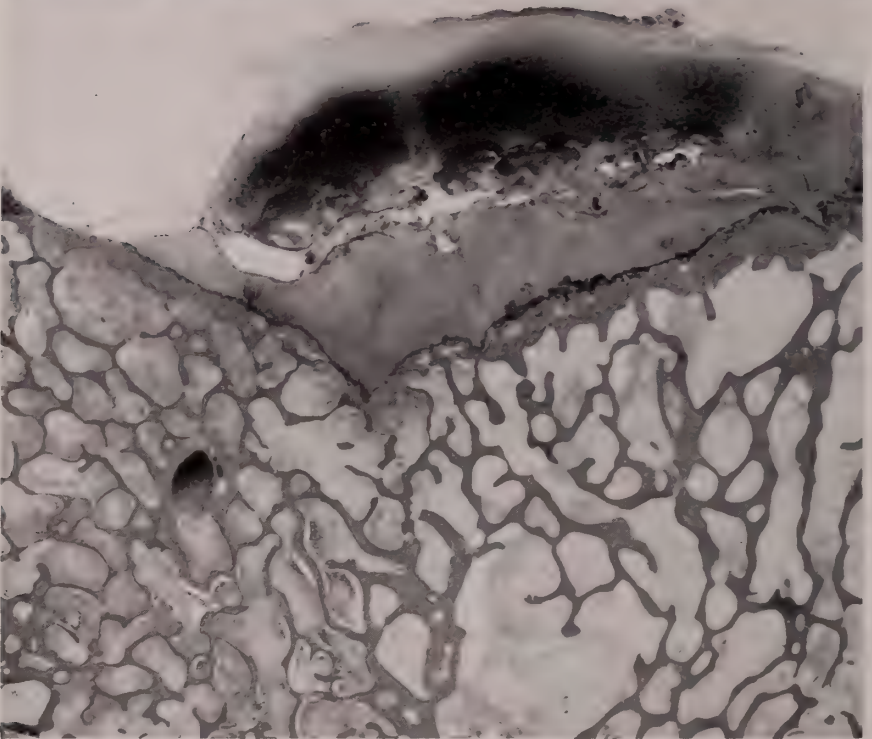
Roentgenograph of a deformed and substantially necrotic femoral head in the case of a man 50 years of age who had pain and disability, of 6 months' standing, referable to the hip. The underlying cause for the necrosis was never clarified.
